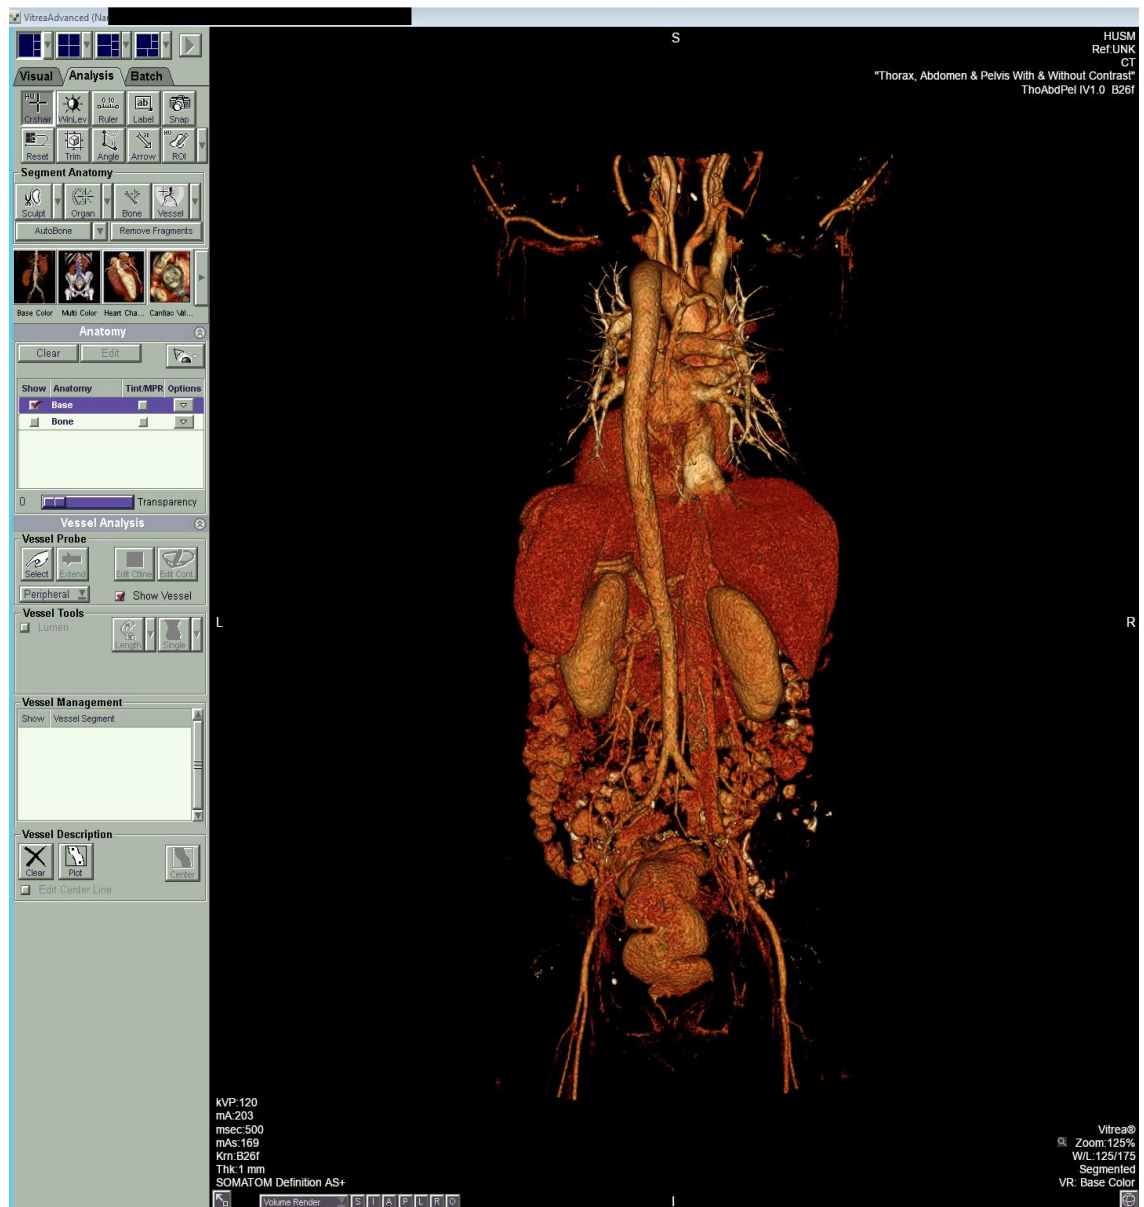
Volume rendered (VR) image of contrast CT thorax, abdomen, and pelvis.
